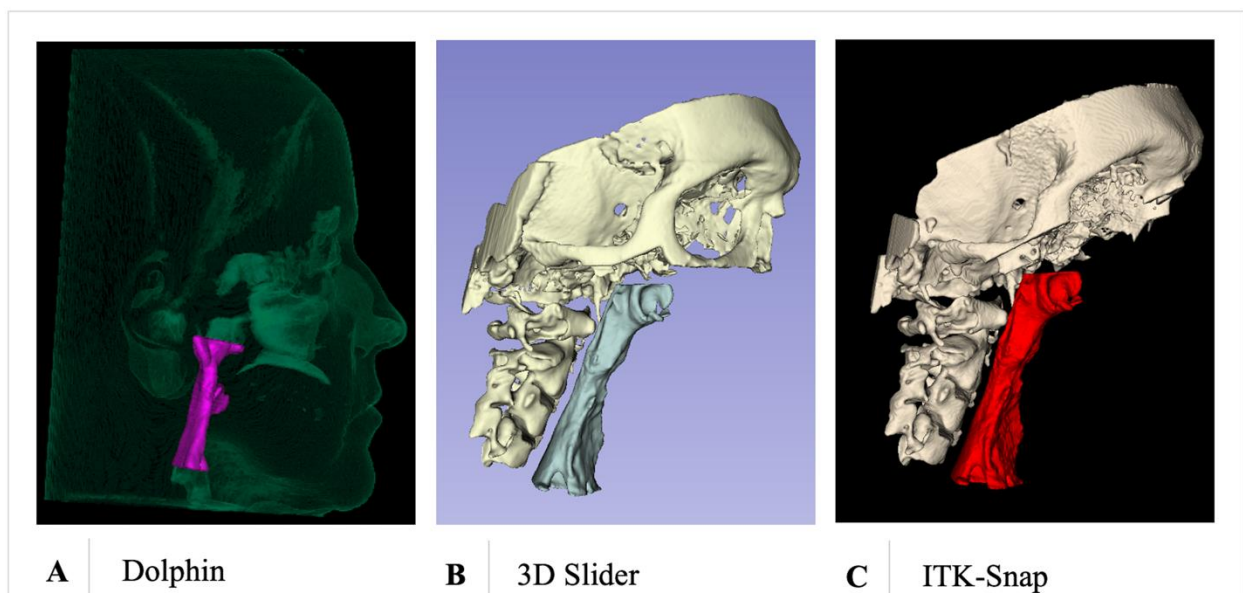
Three-dimensional reconstructions in CBCT different software. (A) Dolphin. (B) IKT-Snap. (C) 3D Slicer.
